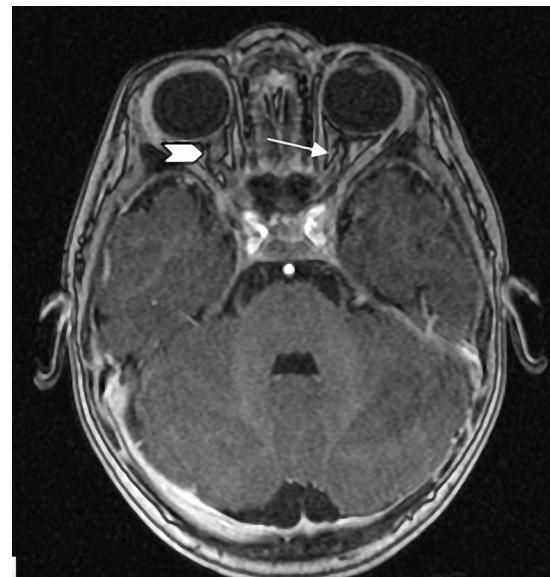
Axial T1 weighted MRI with contrast showing decreased caliber of the left optic nerve (white arrow) compared to the normal appearance of the right optic nerve (arrowhead). The optic nerves are outlined in India ink.
